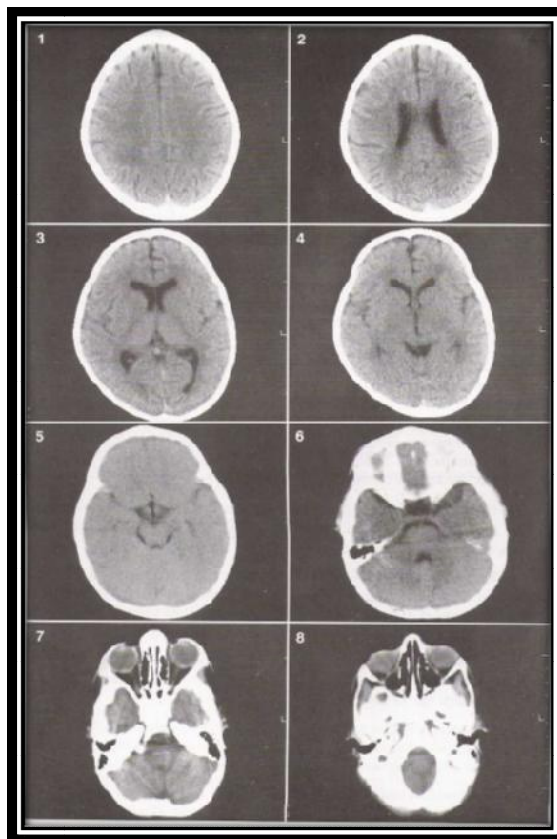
shows a series of sections of normal plain CT scan of children (from 1-8)
